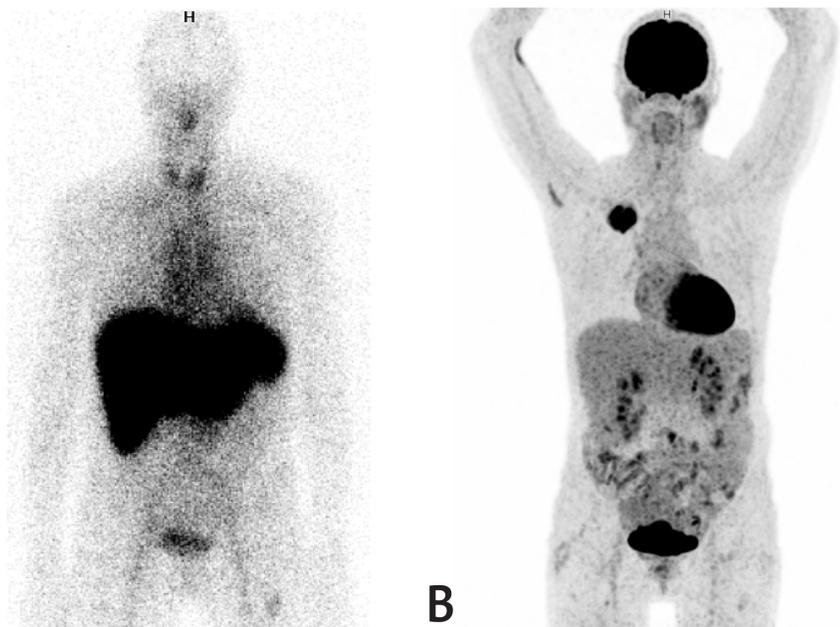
Planar Serum Amyloid P component (SAP) scintigraphy images show increased specific uptake in the liver, and spleen (A). Whole body FDG-PET scan shows increased uptake within the tumour lesion in the right upper lobe (B).
